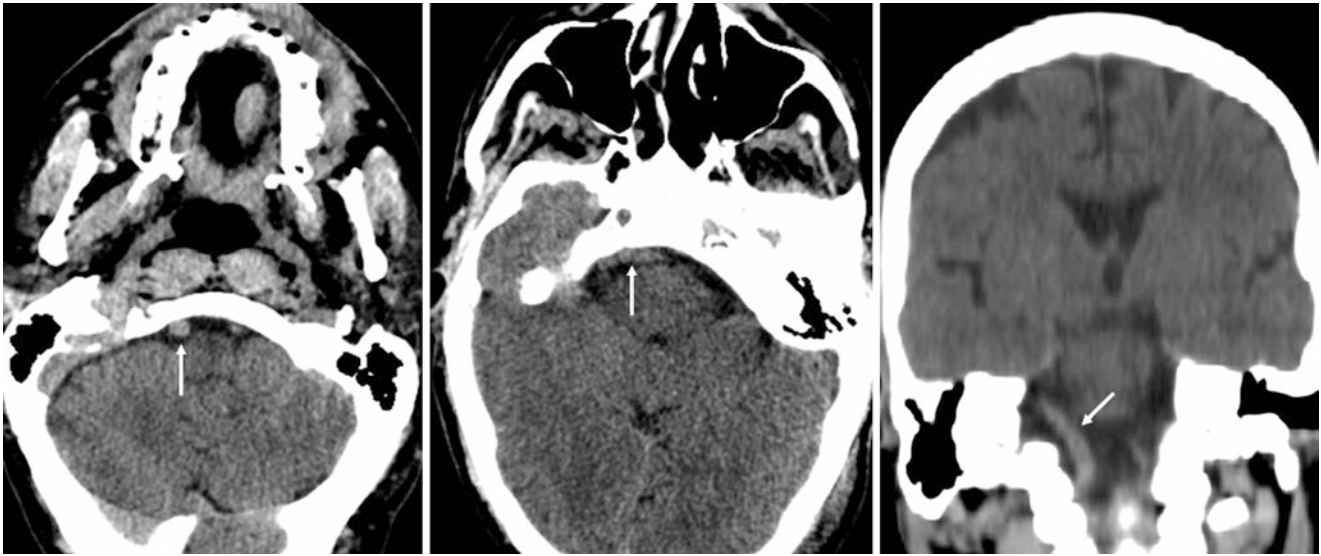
46-year-old with a moderately to severely tortuous, elongated, and mildly ectatic dominant right VA (*arrows*) on nonenhanced CT axial images (*left* and *middle*) and a reconstructed coronal image (*right*). Initially, the artery seemed focally aneurysmal on the axial
